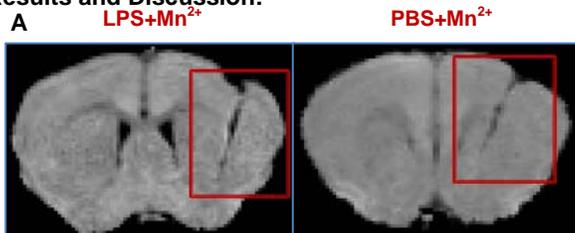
T1-wt MRI images. Signal enhancement around the injection line (encased by red box).
